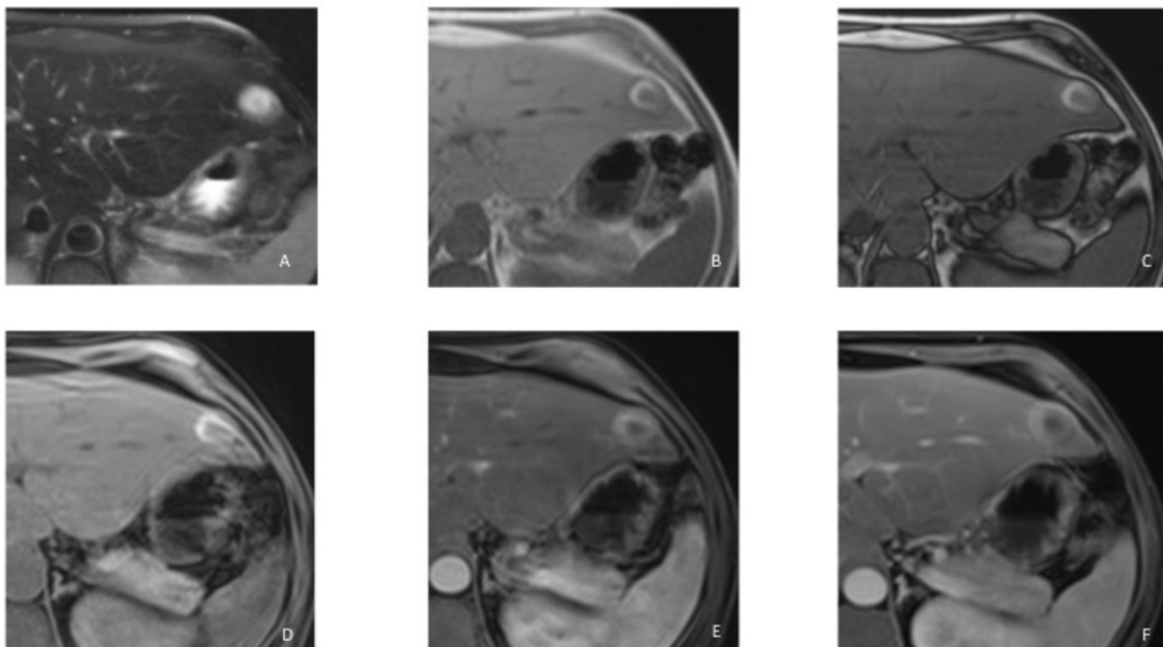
β -catenin-mutated hepatocellular adenoma (β HCA). Axial T2-weighted MR image (A) shows a hyperintense focal lesion (S3), with focal and peripheral hyperintense areas on T1-weighted MR images (B, C, D, E, F, H) - intratumoral bleeding. Axial T1-weighted contrast-enhanced MR images show peripheral arterial enhancement in the arterial phase (E), with no washout in the portal venous phase (F). Axial T1-weighted in-phase (B) and out-of-phase images (C) show a signal drop of the liver on the opposed-phase image -> Diffuse fat deposition.
